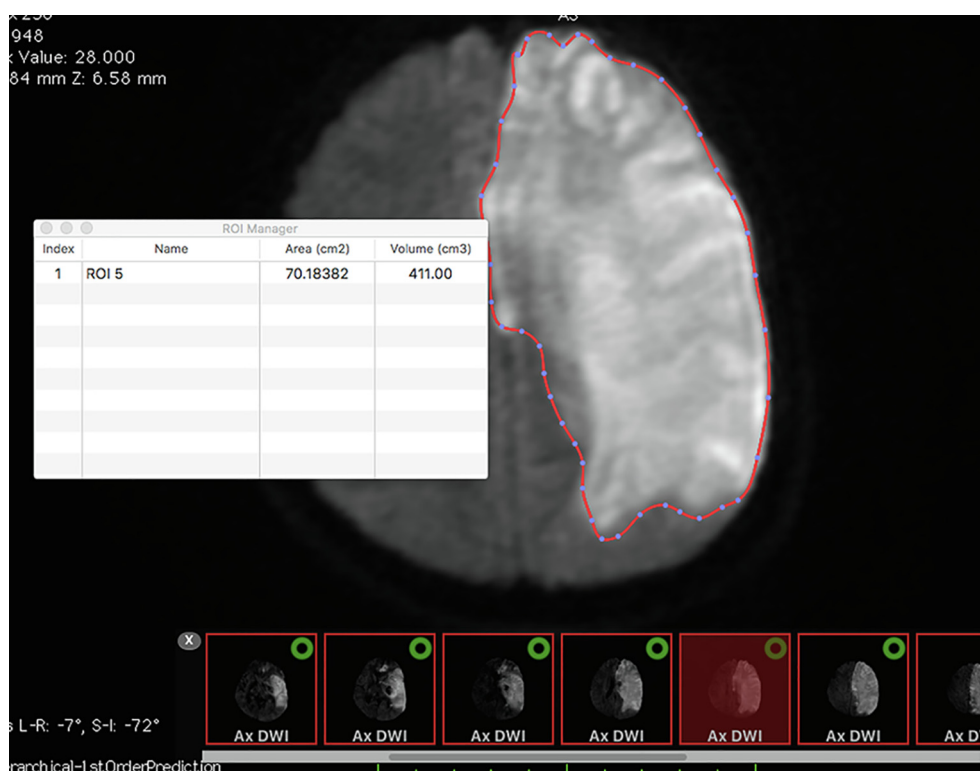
Pre-operative cranial DWI MRI scan with ROI (region of interest) images at the bottom. The volume of the ischemic cerebral tissue was calculated using ROI manager tool of OsiriX® DICOM image processing software (Pixmeo SARL, Bernex, Switzerland) and found to be 411 cm³.
